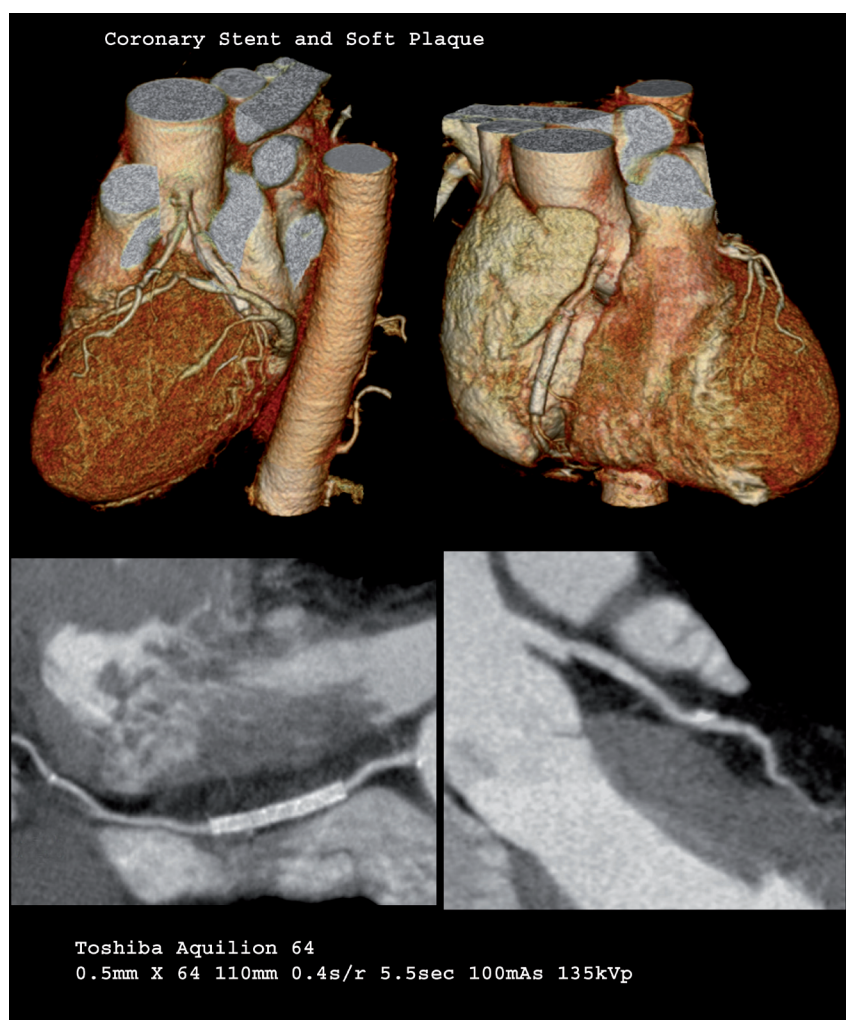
Post-stent multislice CT evaluation. (Courtesy Toshiba.)
